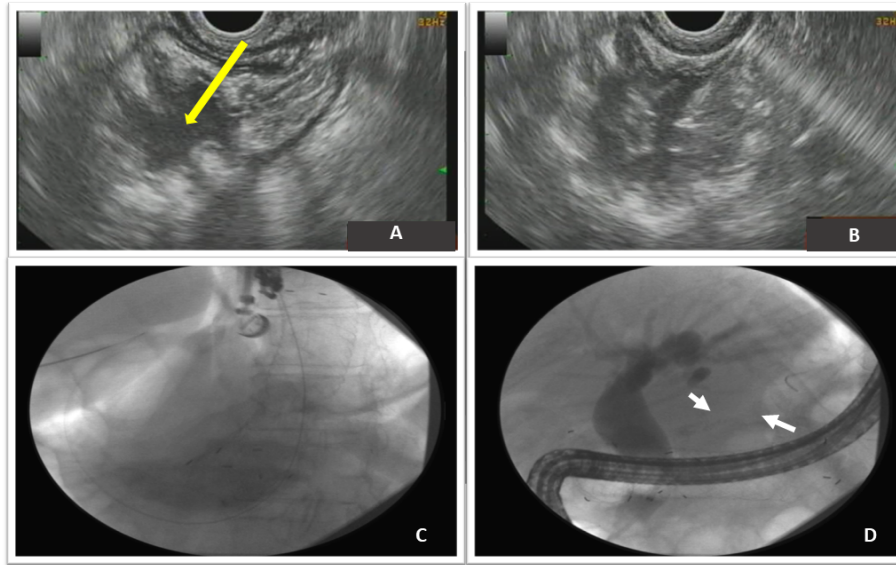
A. Endoscopic ultrasound (EUS)-guided image showing the gastric remnant (yellow arrow) from the gastric pouch in a RYGB patient. B. EUS-guided image showing a puncture of the excluded stomach remnant with a 19G EUS-fine needle aspiration (FNA). C. Fluoroscopic image of a transgastric 20 mm duodenal PC-SEMS. White arrows indicate a waist in the gastro-gastric anastomosis D. Fluoroscopic image of the ERC through the deployed a transgastric stent.
